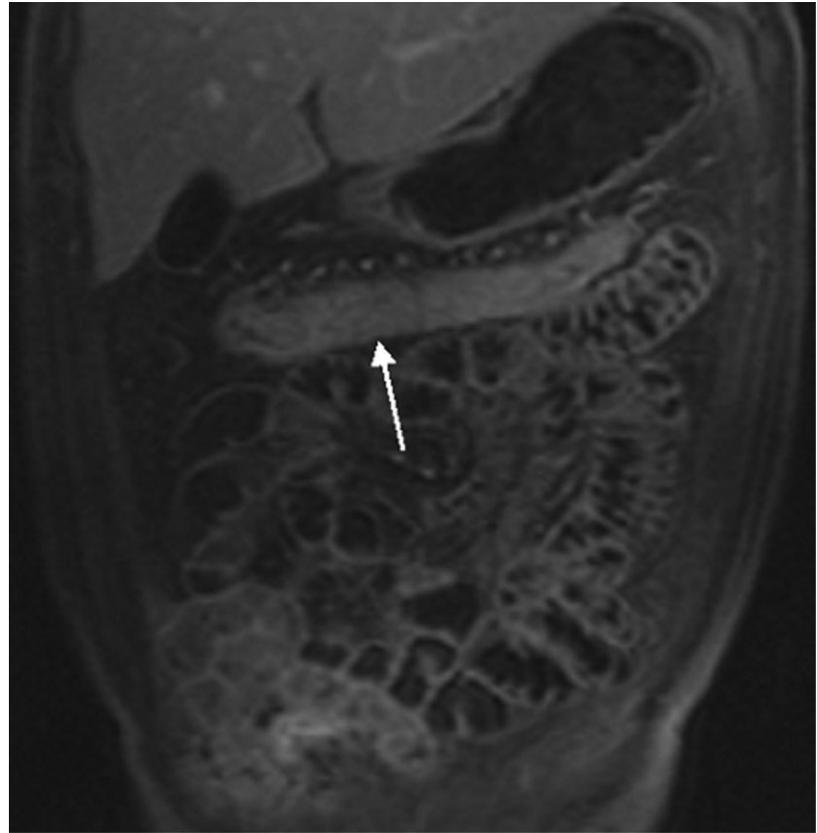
Hydro-MRI without a rectal enema of a 41-year-old male patient with known Crohn's disease. The colonic segments like the transverse colon (arrow) show an insufficient distension. Conventional colonoscopy diagnosed an acute inflammation in the transverse colon that was missed in MRI.
